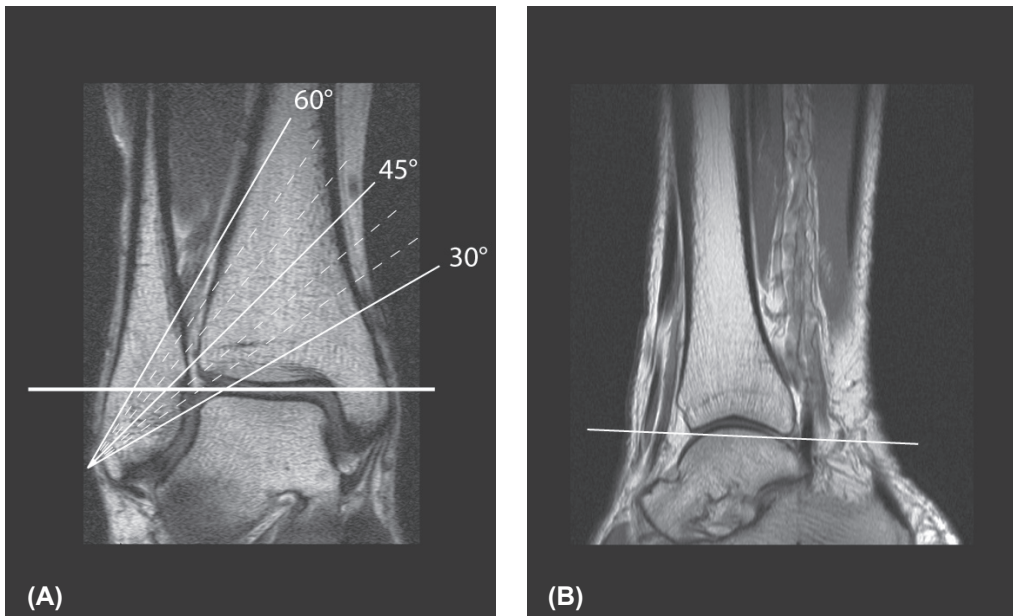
Coronal (A) and sagittal (B) MR images, which indicate the angle of the oblique image plane for the anterior and posterior distal tibiofibular ligament. In the coronal plane the angle varied from 35 to 60°, with steps of 5°. In the sagittal view the direction of the oblique plane runs parallel to a line along the inferior border of the anterior and posterior tibia.
